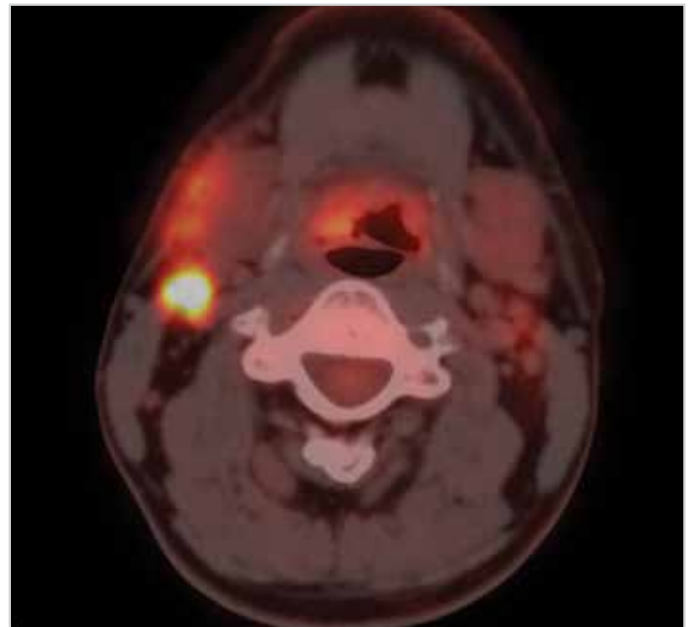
PET-CT axial image of the patient having SUV-max value of 15.4 at the right first region
